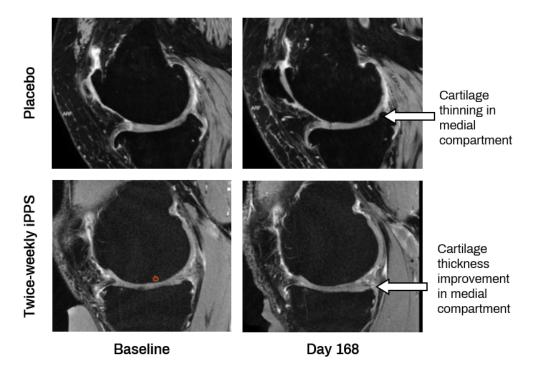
Representative side-on (sagittal) MRI images from PARA_OA_008 of the knee at baseline (left panels) and at Day 168 (right panels) from a participant receiving placebo (top panels) and a participant receiving twice weekly iPPS (bottom panels) demonstrating changes in cartilage thickness in the medial compartments. In the twice weekly iPPS baseline image, there is a small bone marrow lesion in the subchondral bone (bone that is directly under cartilage) of the femur (circled in red), that is resolved at Day 168.
